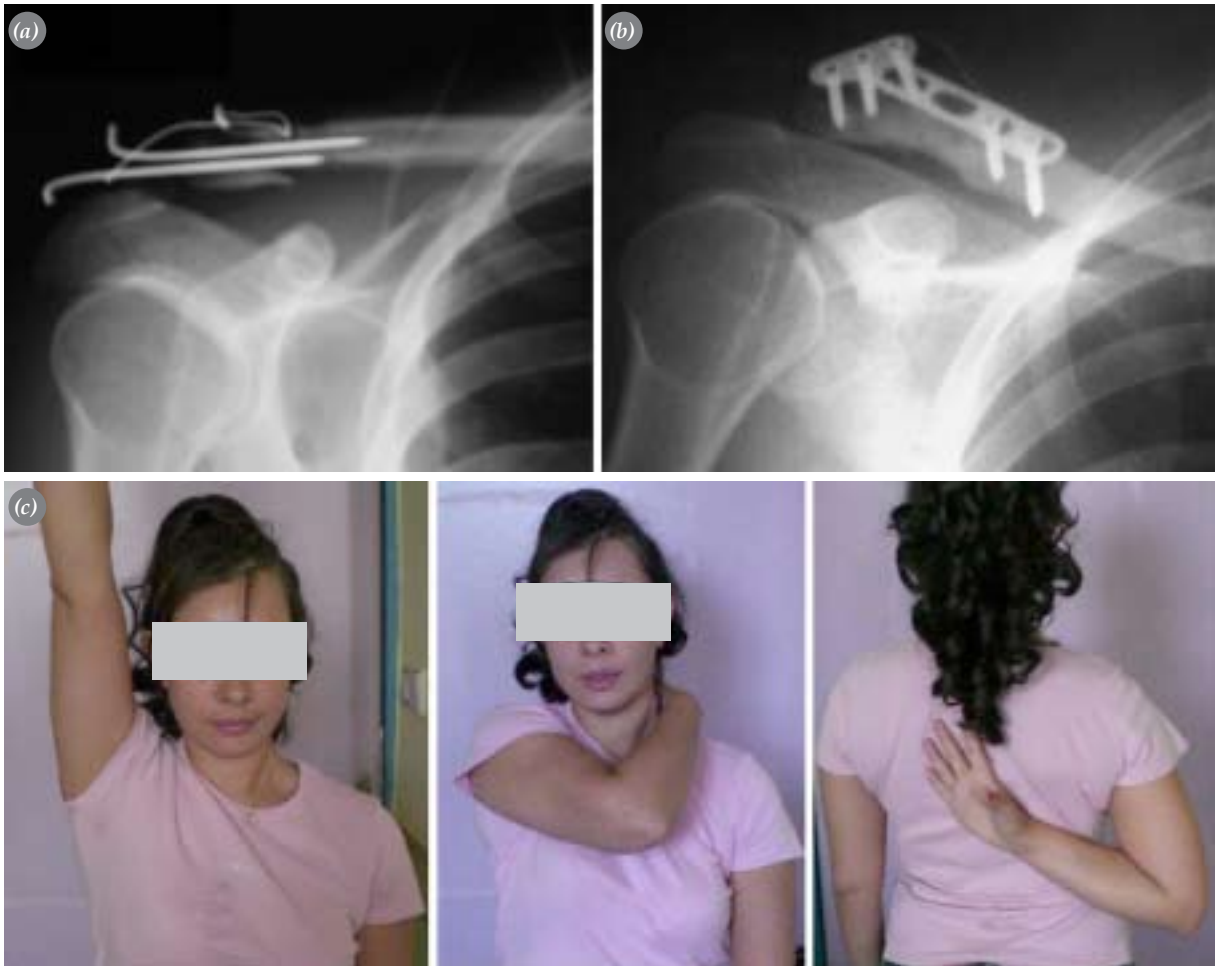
Thirty six years old female medical dentist was involved in a car traffic accident and sustained a displaced right clavicle distal end fracture. Operative treatment by using open reduction and K wire-cerclage wiring technique was performed at a different hospital. After four months she admitted to our department with pain on shoulder motions and skin irritation due to protruding K wires and cerclage knot. Clinical examination revealed decreased shoulder motion in all directions and tenderness on palpation over the prominent implant. Direct X-rays revealed, defective fracture healing at the fracture site and loosening of wires (a). Operative treatment was advised. After implant removal fracture site was debrided and fixed with fixed angle distal radius plate. No bone grafting was performed. Fracture united uneventfully (b). Three months postoperatively patient was completely pain free with full range of motion (c,d and e).
